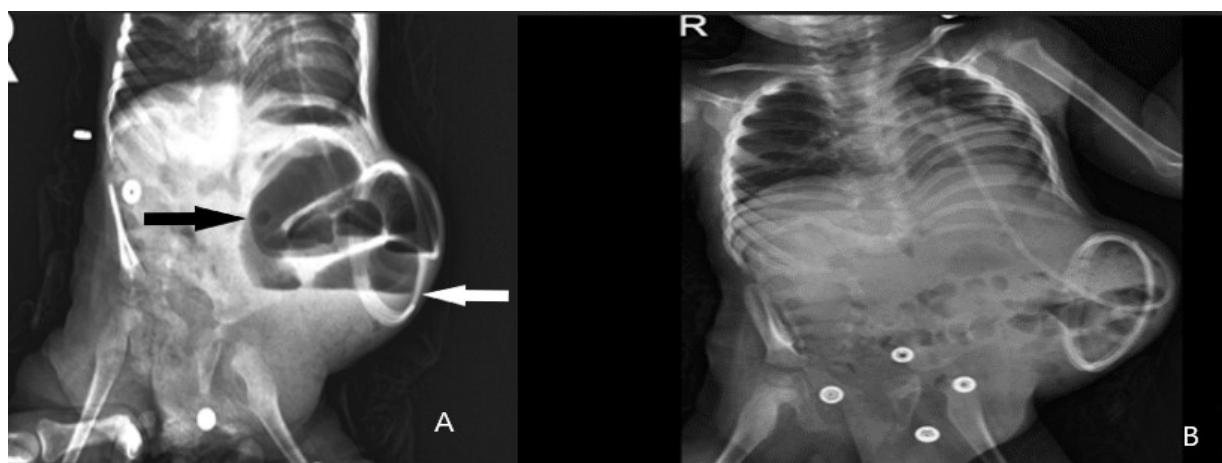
A- Direct abdominal radiography before treatment: mechanical obstruction of small bowel from distal peritoneal catheter (white arrow) wrapped around the loop of ileum. Abdominal distention, intestine dilatation, air-liquid levels (black arrow). B- Direct abdominal radiography after conservative treatment, obstruction was resolved.
